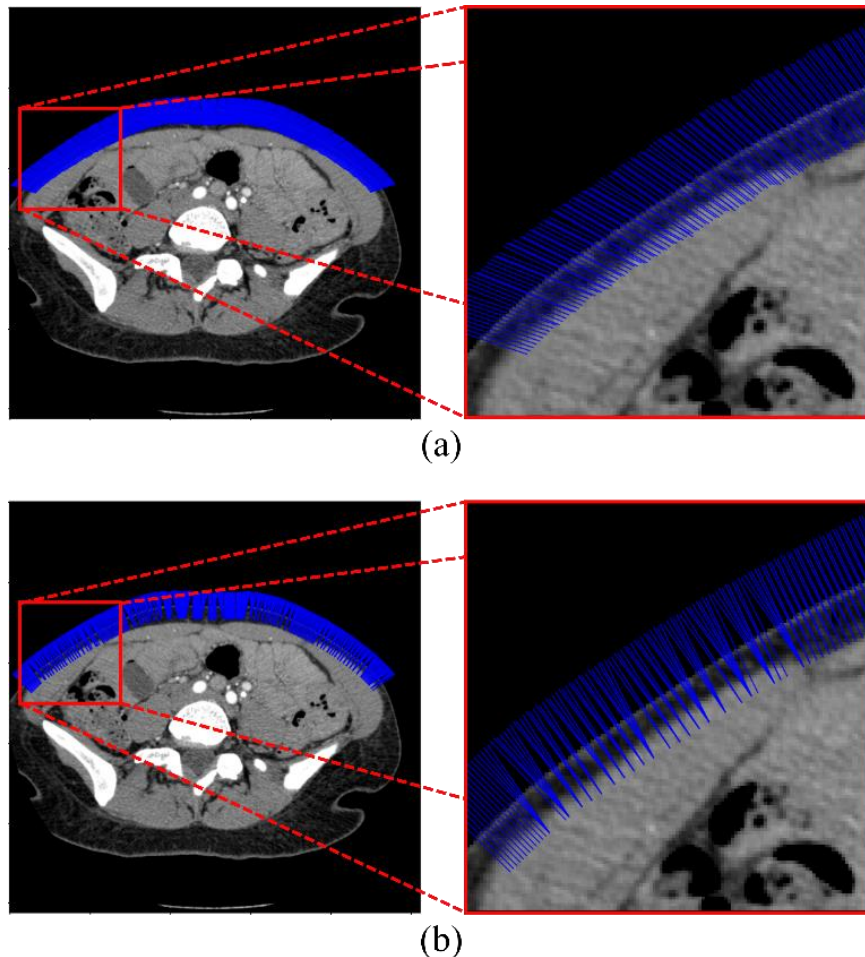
ROI placement on a patient's CT image (abdomen). (a) ROI placement using DT-ROI and (b) ROI placement using SR-ROI.
